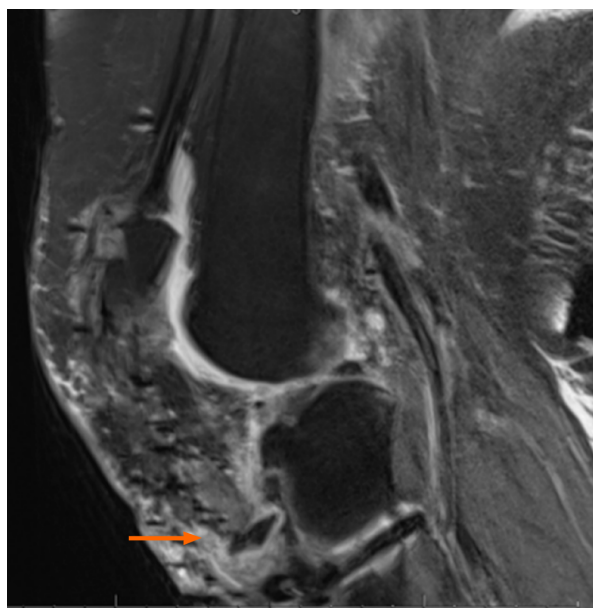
Preoperative sagittal magnetic resonance imaging. (Proton Density weighted image fat saturation)-demonstrates avulsion fracture of the tibial tuberosity with patellar tendon rupture and patella alta.
